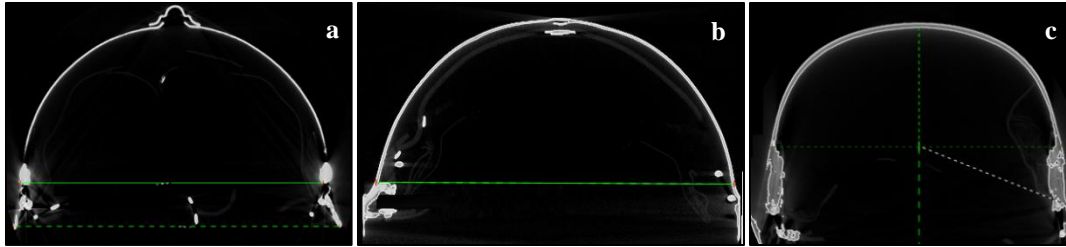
Coronal CT sections of (a) Adrian helmet, (b) Brodie helmet, (c) Stahlhelm. The Adrian helmet (a) is the thinnest steel followed by the Brodie (b) and the Stahlhelm (c).
